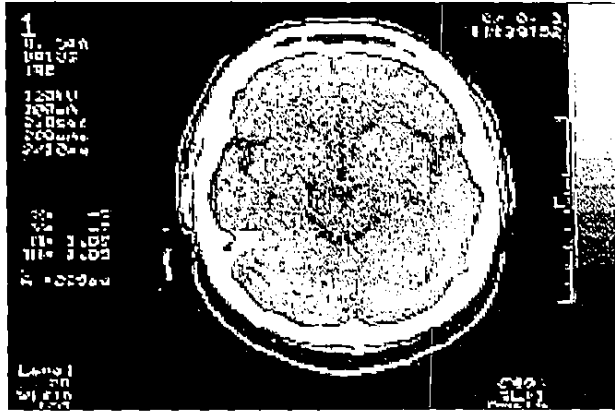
Cranial CT at the level of the midbrain, demonstrating normal anatomy without evidence of hemorrhage or infarction within the brainstem.
